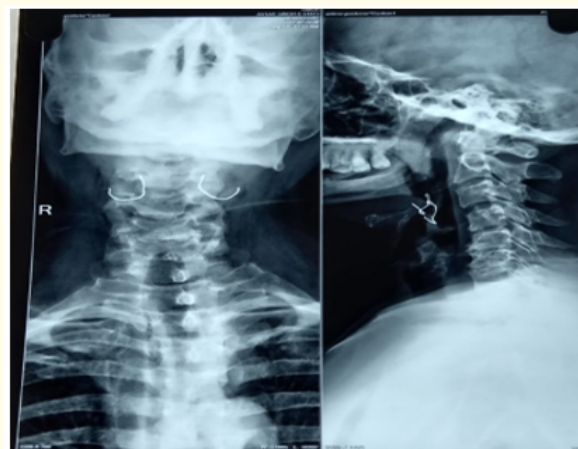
Soft tissue neck radiograph (AP and Lateral views) demonstrating radiopaque metallic sidewires embedded at the level of the hyoid bone and epiglottis.
